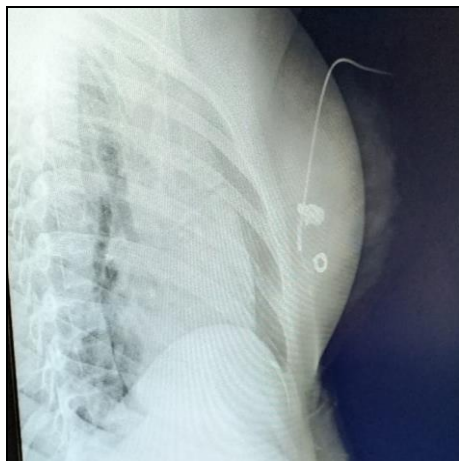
X-ray sinogram – lateral view
